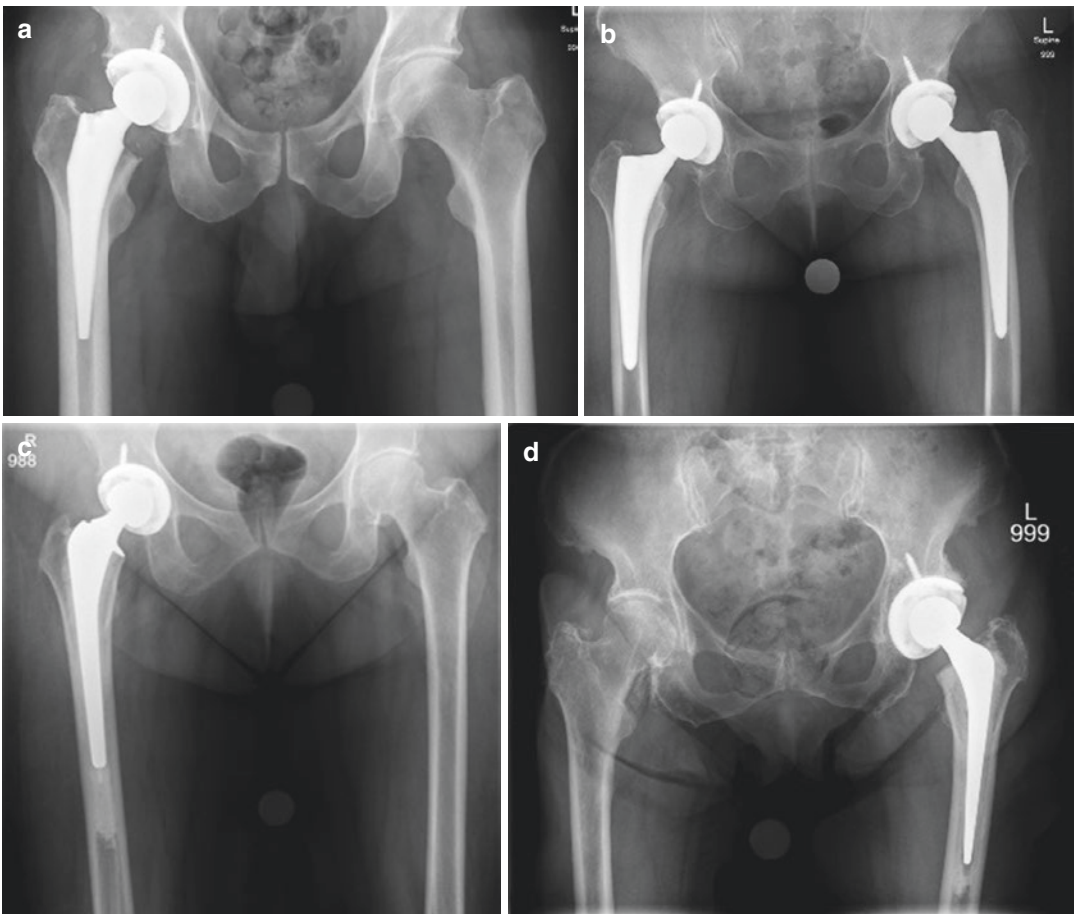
Anteroposterior (AP) pelvis radiographs of femoral implant types implanted with a non-cemented hemispherical acetabular component using the anterior-based muscle-sparing (ABMS) approach. (a) Blade-style, single-taper, metaphyseal ingrowth stem (Anthology AFIT, Smith and Nephew, Memphis, TN, USA). (b) Double-taper, full
